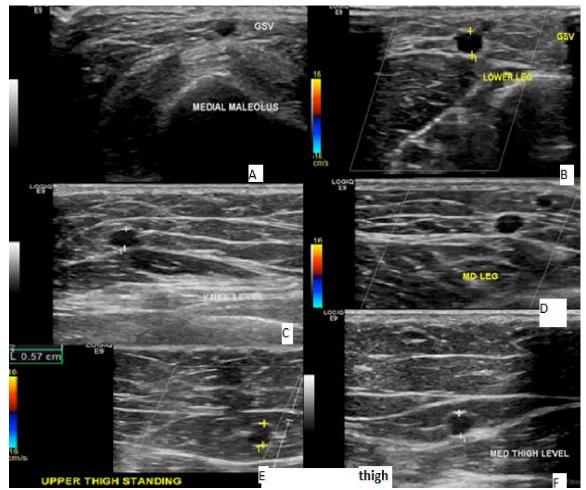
Doppler study for Saphenous vein course at: A) The malleolus, B) lower leg, C) Knee level, D) Mid-leg, E) Upper thigh with bifurcating vein, F) Mid-thigh.
